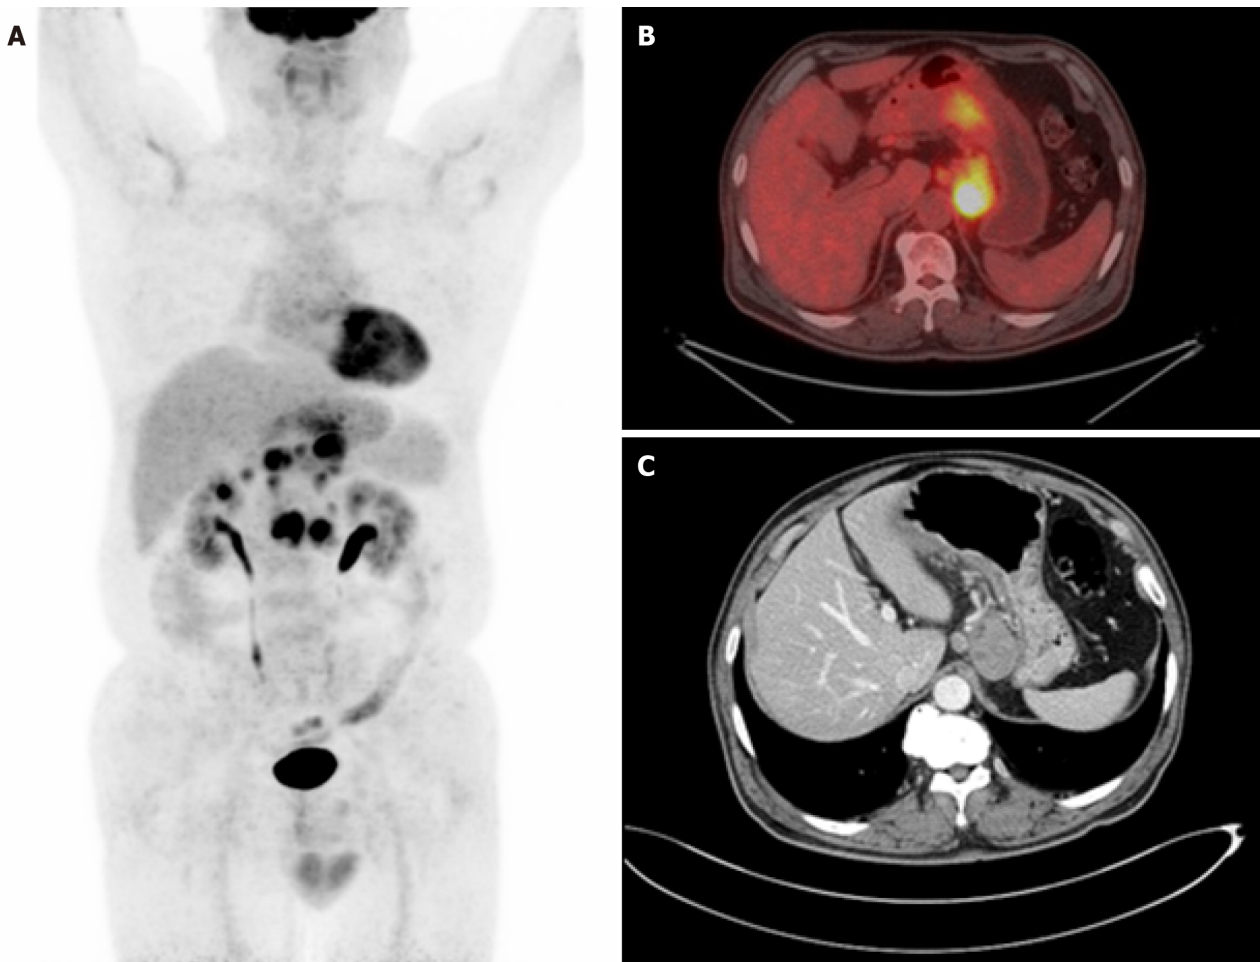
Underwent imaging. A and B: Positron emission tomography showed hypermetabolic mass located in the lower body; C: Computed tomography showed diffuse wall thickening of the posterior lesser curvature of the gastric body with metastatic nodes.
